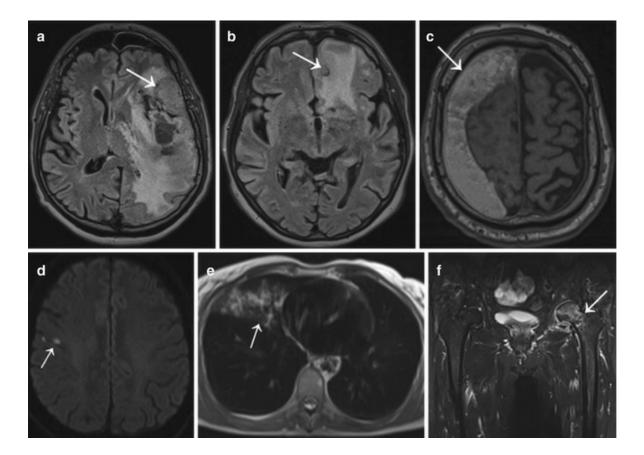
Category III incidental findings on whole-body MRI. *Arrows* indicate the abnormalities. (a) Meningioma of the left sphenoidal wing (diameter 42 mm). (b) Metastasis (diameter 13 mm) of unknown primary in the left frontal lobe. Both show marked surrounding edema of the white matter on fluid-attenuated inversion recovery axial images. (c) A fluid-attenuated inversion recovery axial images. (d) Diffusion-weighted echo-planar image shows a small area of acute cortical ischemia. (e) T2-weighted half-Fourier acquisition single-shot turbo spin-echo image displays lobar pneumonia of the right middle lobe. (f) Turbo inversion recovery magnitude coronal image shows extensive bone edema of the left femoral head and neck (Image and text taken from Hegenscheid et al. (2013))
